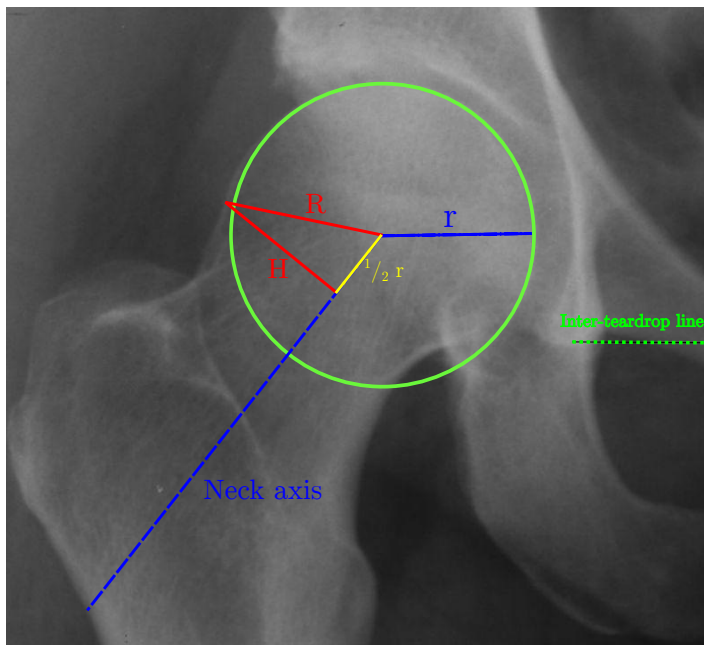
The radius (r) of the femoral head is measured and at $1/2r$ along the neck axis the corresponding perpendicular height (H) to the cortex is measured. The perpendicular height is termed Triangular Index Height (TIH). Triangular index is defined as positive if $R > r + 2$ mm on a radiograph, with 1.2 magnification. Triangular index has been used previously to identify cam deformity and is highly related to alpha-angle [77].
